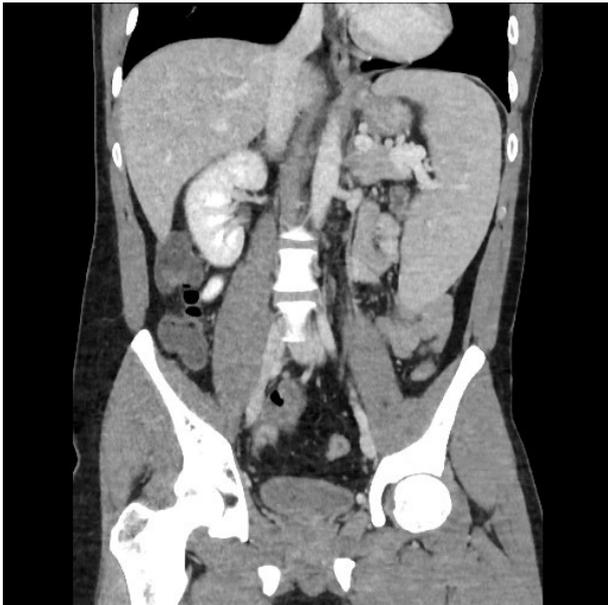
CT scan with splenomegaly.
